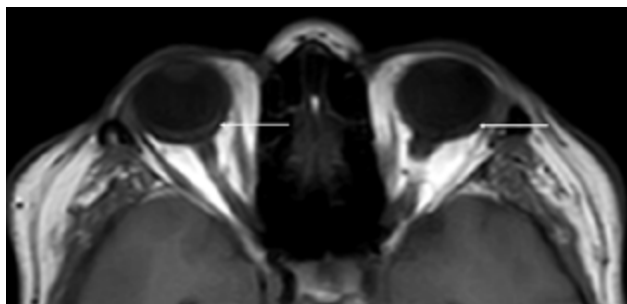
MRI of a 50-year-old woman presenting with headache, bilateral posterior uveitis, and retinal vasculitis. Axial T1WI sequence showing a thickened posterior segment of the ocular globe (arrows).
